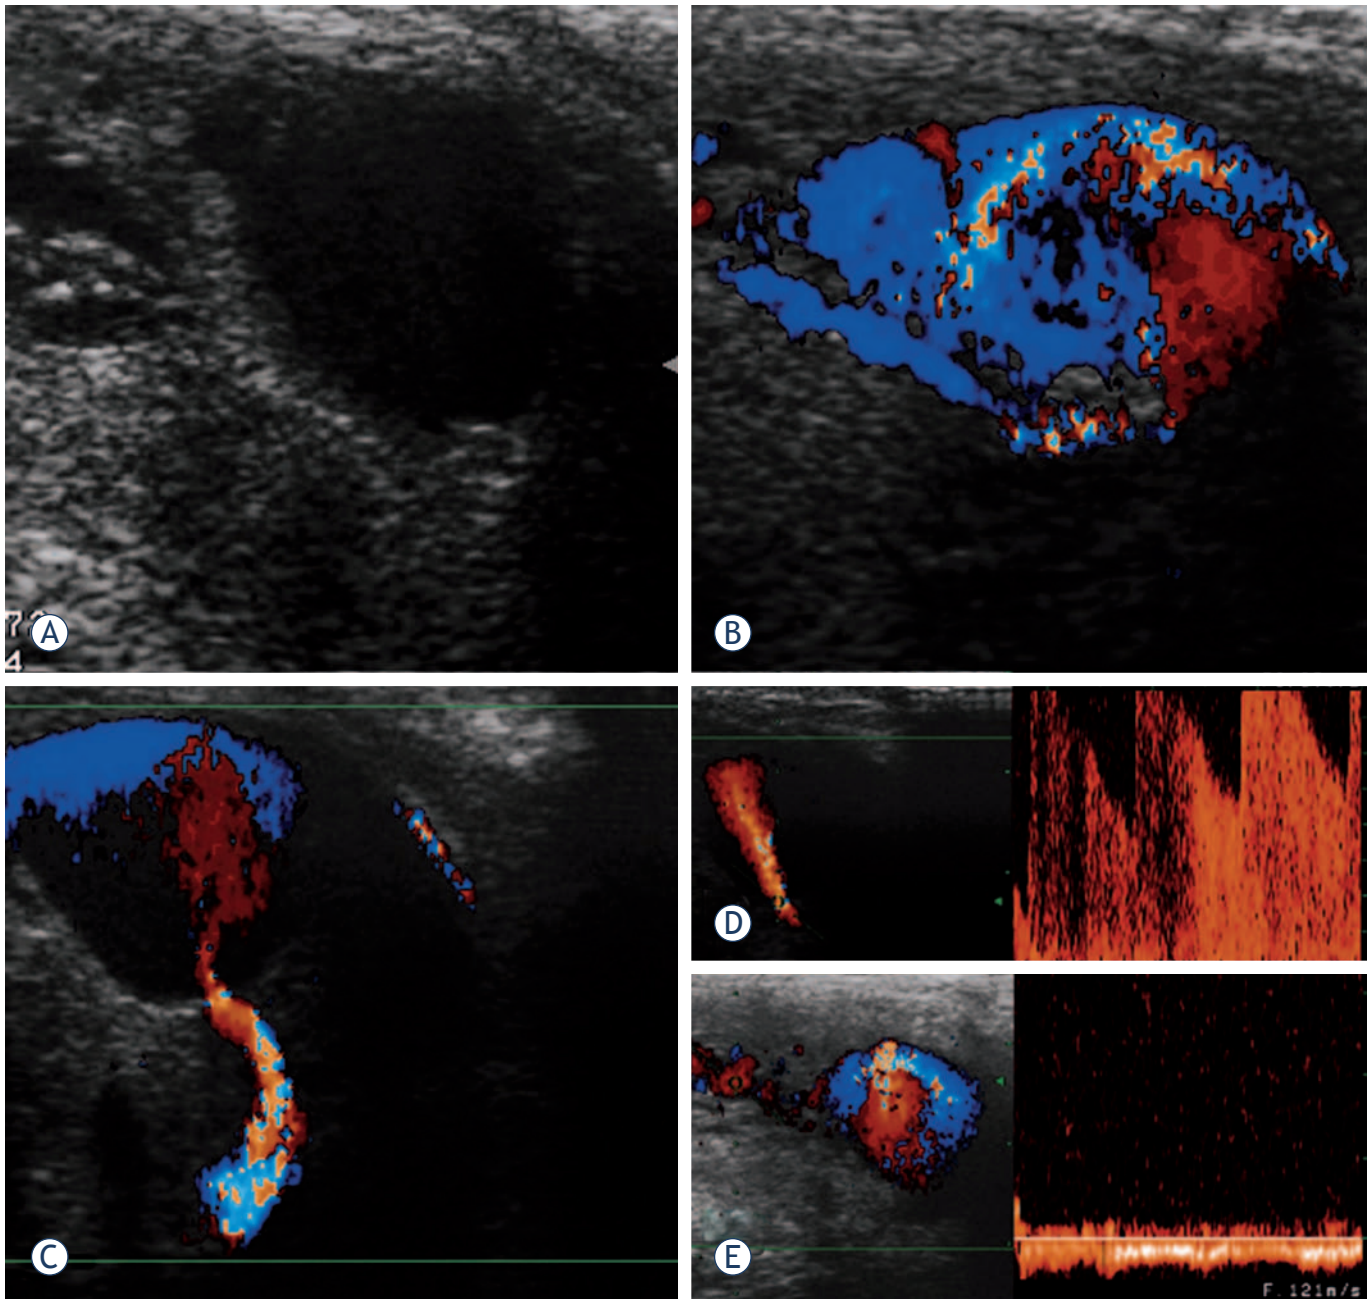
A. Gray-scale ultrasound depicts anechoic region, within corpus cavernosum. B. Colour Doppler ultrasound with multiple colour signals. C. Doppler sonogram of cavernous artery which fills the pseudoaneurysm. D. Pulsed Doppler analysis with aliasing phenomena due to turbulent high-velocity flow in the cavernous artery. E. Venous drainage in the corpora cavernosa on Doppler sonogram.
